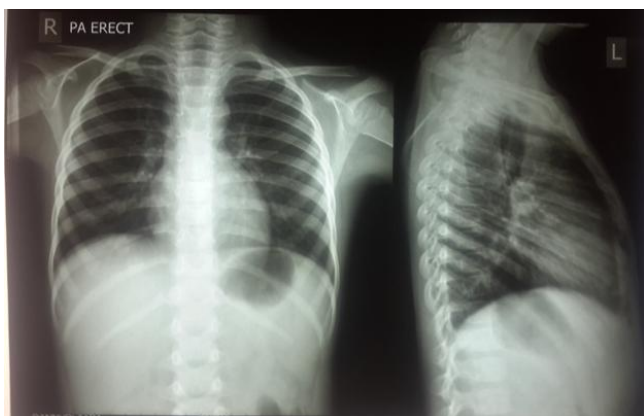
Chest X-Ray Post Operation
